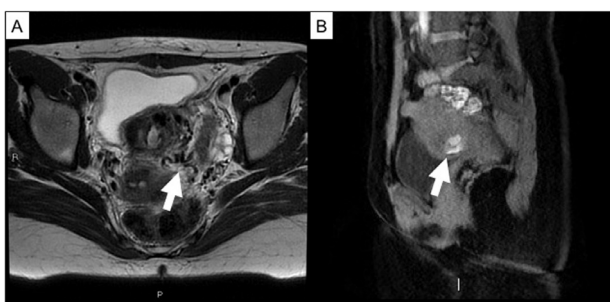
Same patient of Fig. 1. T2-weighted MR (A) in axial plane, white arrow showing a serpiginous vascular structure in the uterine wall; (B) Contrast-enhanced T1-weighted MR in sagittal plane acquired in precocious arterial phase showing a focal area of tubular enhancement (white arrow) corresponding to the AVM.
